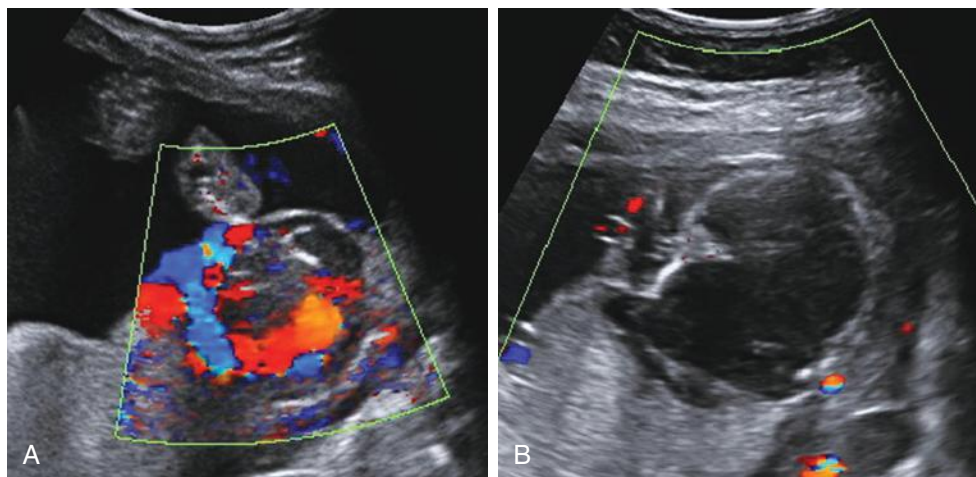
Placental chorioangioma. A, Color Doppler sonography at 25 weeks' gestation reveals a large, markedly vascular, well-circumscribed mass protruding from the fetal surface of the placenta. B, Sonogram performed at 29 weeks' gestation, following laser photocoagulation of the feeding vessels. The chorioangioma has decreased in size, appears predominantly cystic, with no demonstrable internal flow shown by color Doppler interrogation.
